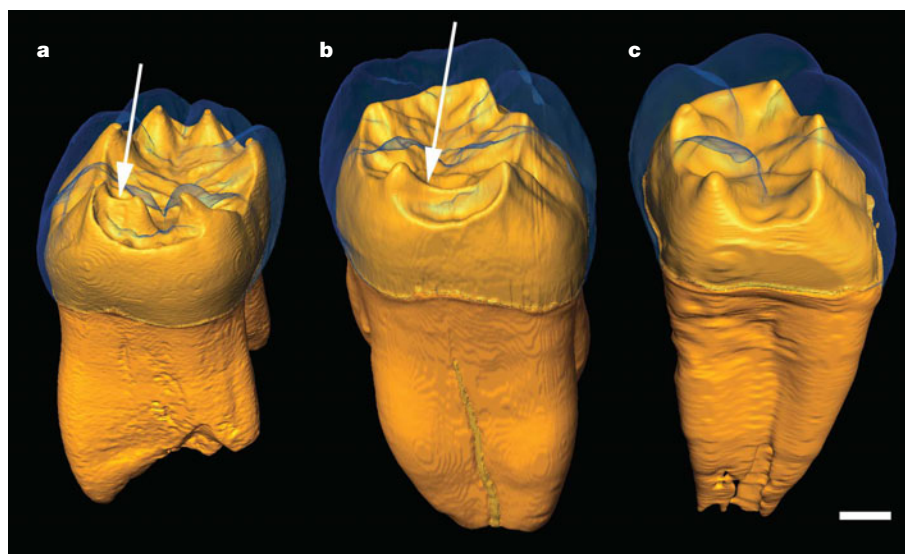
SR- μ CT-based three-dimensional virtual reconstruction of deciduous and permanent Neanderthal molars from La Chaise. The transparent enamel caps are compared with a modern human permanent molar (slightly oblique mesiobuccal views). a, Neanderthal lower right deciduous second molar (LRm2). b, Neanderthal lower left permanent first molar (LLM1). c, Modern human lower M1. In each of the molars from La
